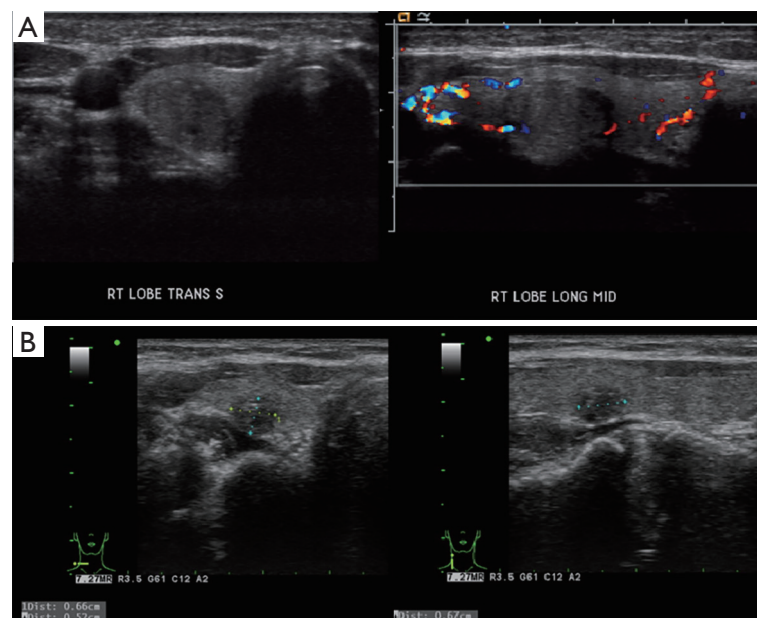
These images demonstrate ultrasound regression of the lesion over a period of 4 years. (A) Initial ultrasound; (B) follow up ultrasound 4 years later.
